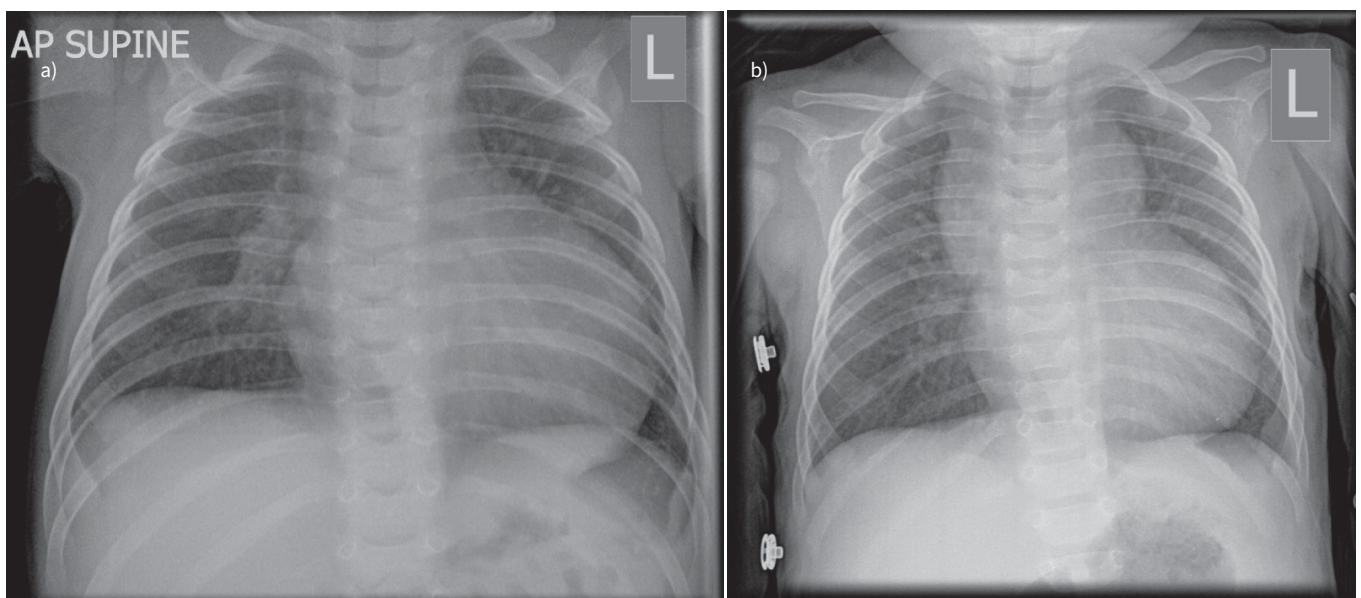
a) Chest radiograph pre-discharge; b) follow up in clinic 6 weeks later.
